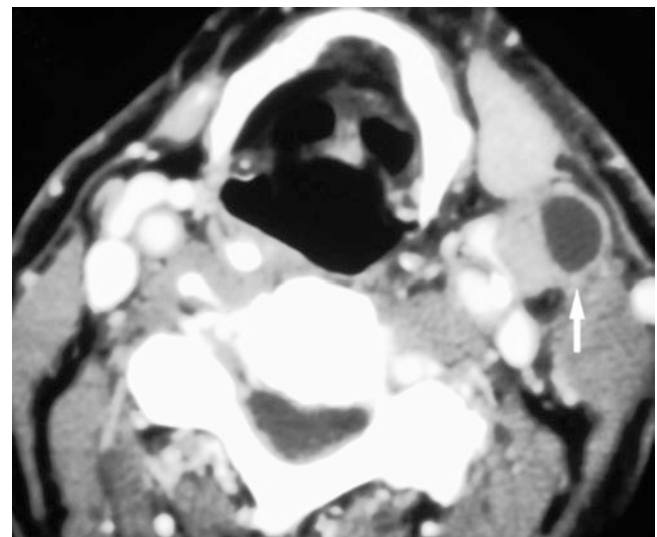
Lymph node metastasis; 65-year-old male with squamous cell carcinoma of left palatine tonsil, metastasizing. Axial post-contrast CT image shows well-defined mass in submandibular space, hypodense with enhanced border (*arrow*). Note similarity with branchial cleft cyst in Fig. 11.21
